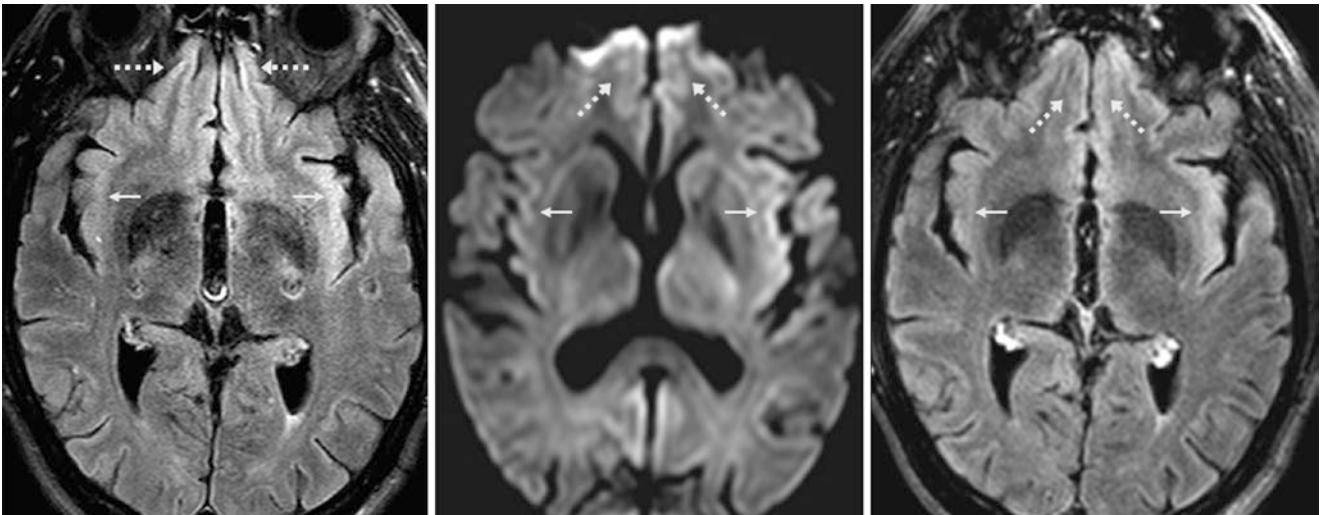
A 64-year-old underwent a 3 T MRI that shows asymmetrically hyperintense left insular cortex (*thin arrows*) and left orbitofrontal gyri (*dashed arrows*) on FLAIR (*left*) and DWI (*middle*). Repeat
